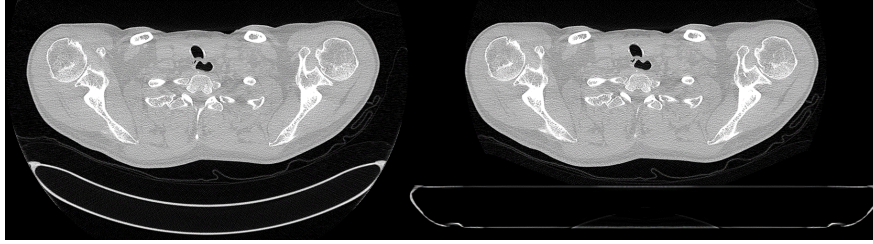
On the left, a slice of the clinical CT scan and on the right, the same slice with the Ethos couch inserted.
